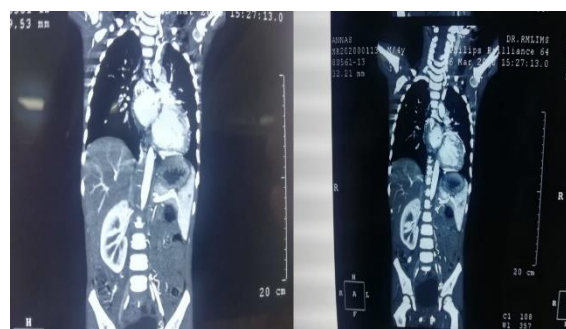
CT angiography of thorax and abdomen
